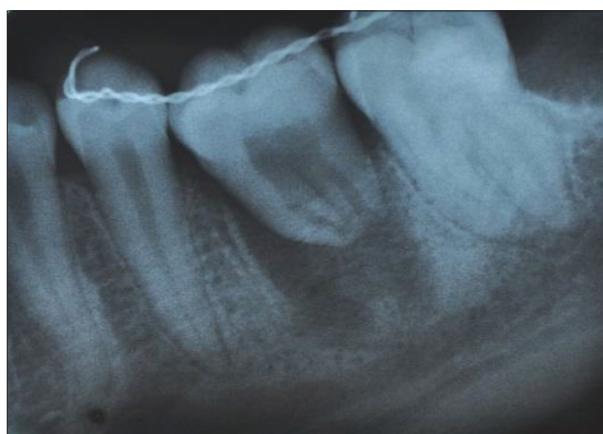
Radiographic finding of the transplanted and splinted lower right wisdom tooth
